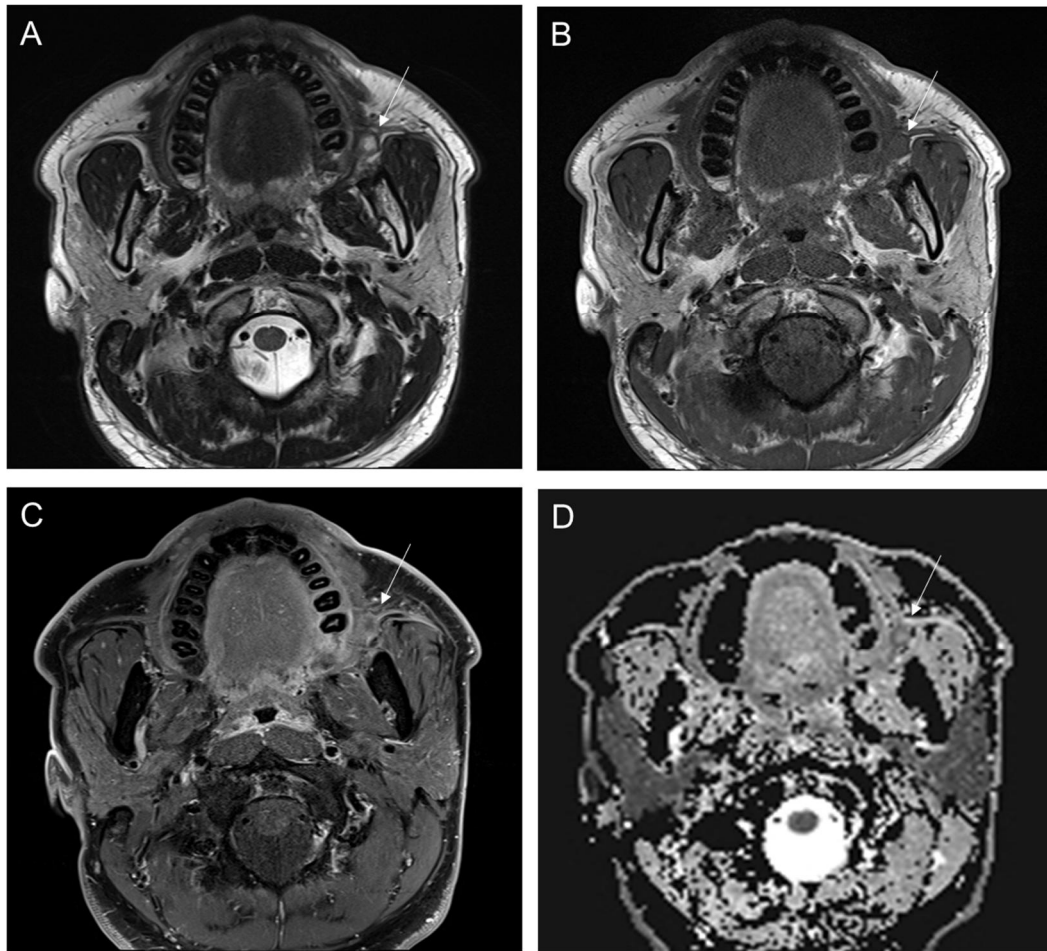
(A-D) Case of local recurrence. 53-year-old man with buccal cancer received marginal mandibulectomy and radical neck dissection. On surveillance MRI after 2 months, enhancing lesion was detected on operation site.
